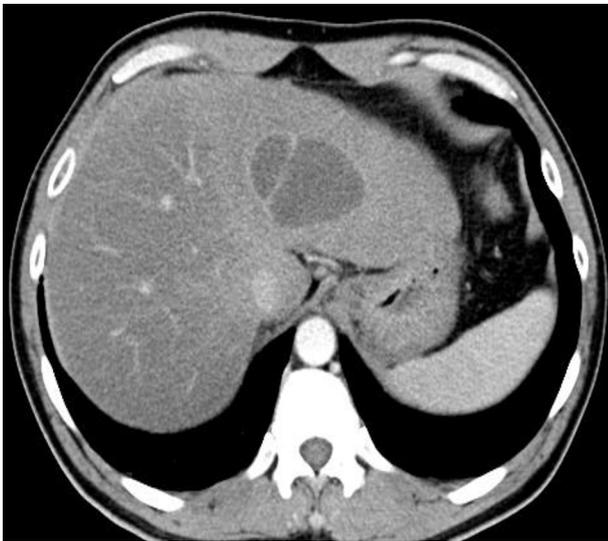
Computed tomography revealed a cystic lesion about 6.4 cm with a thin enhancing wall on left hepatic lobe.
